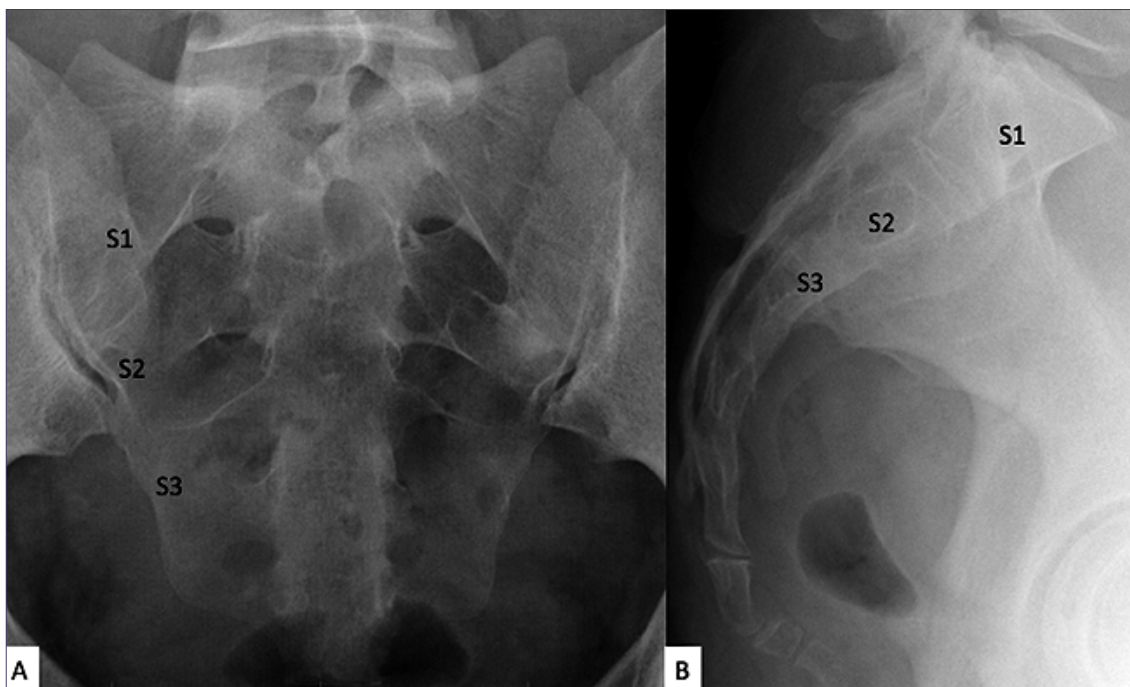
Radiographic projections for planning percutaneous sacroplasty. A: Anteroposterior projection: the sacral foramina S1, S2, and S3 are clearly identified, useful as references for plotting safe trajectories and avoiding foramen violation during trocar placement; B: Lateral projection: allows assessment of the craniocaudal orientation of the sacral vertebrae and planning of the access depth, with direct visualization of the bodies of S1, S2, and S3.
